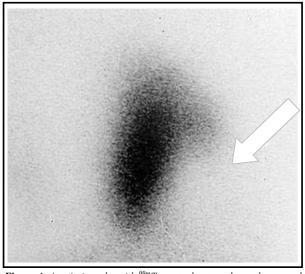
At scintigraphy with ^{99m}Tc pertechnetate shows the normal contrast uptake of the right lobe and no contrast uptake on the left lobe area (arrow).
